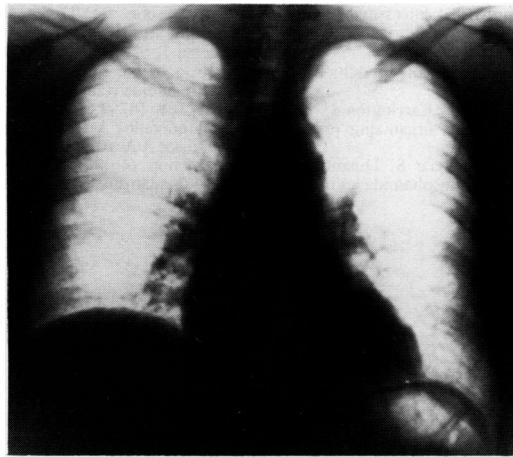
Chest radiograph after treatment.
